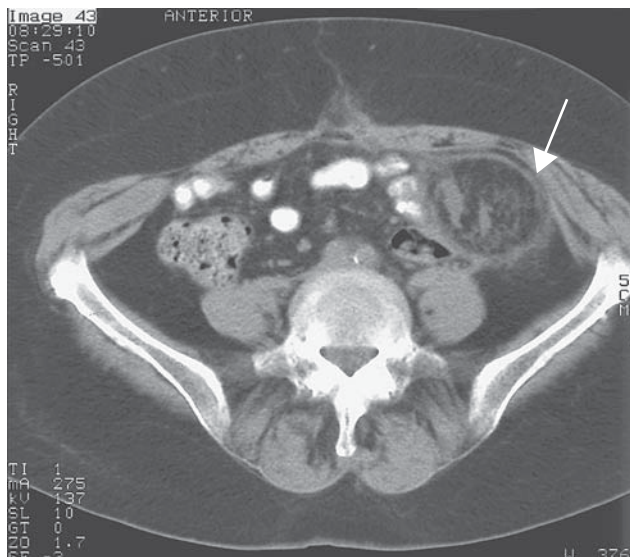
CT examination (10.10.96) shows the left-sided abdominal mass (arrow) prior to laparotomy on 3.3.97.
